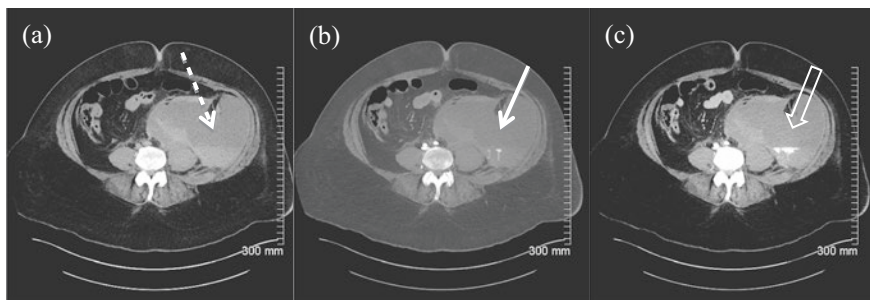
Triple phase CT Abdominal Angiogram showing large left sided retroperitoneal hemorrhage. Noncontrast imaging in image a shows large volume left-sided retroperitoneal fluid, with layering, demonstrated by the broken arrow. This is consistent with hemorrhage. There is an active blush on the arterial phase (denoted by the white arrow in image (b)) with progressive contrast extravasation on the delayed phase (denoted by the empty arrow in image (c)). This patient presented in hypovolemic shock having recently been commenced on warfarin therapy for atrial fibrillation. The patient was subsequently referred for emergency embolization
